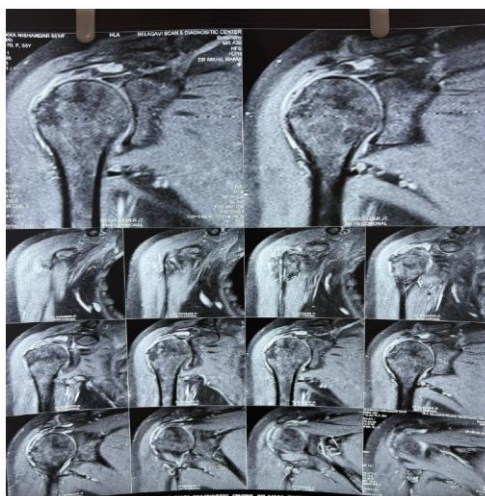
Case 1 — Complete (full-thickness) supraspinatus tear. Coronal oblique fat-suppressed PD/T2-weighted images showing a full-thickness defect of the supraspinatus tendon with fluid signal traversing its entire width, in a 55-year-old female.
